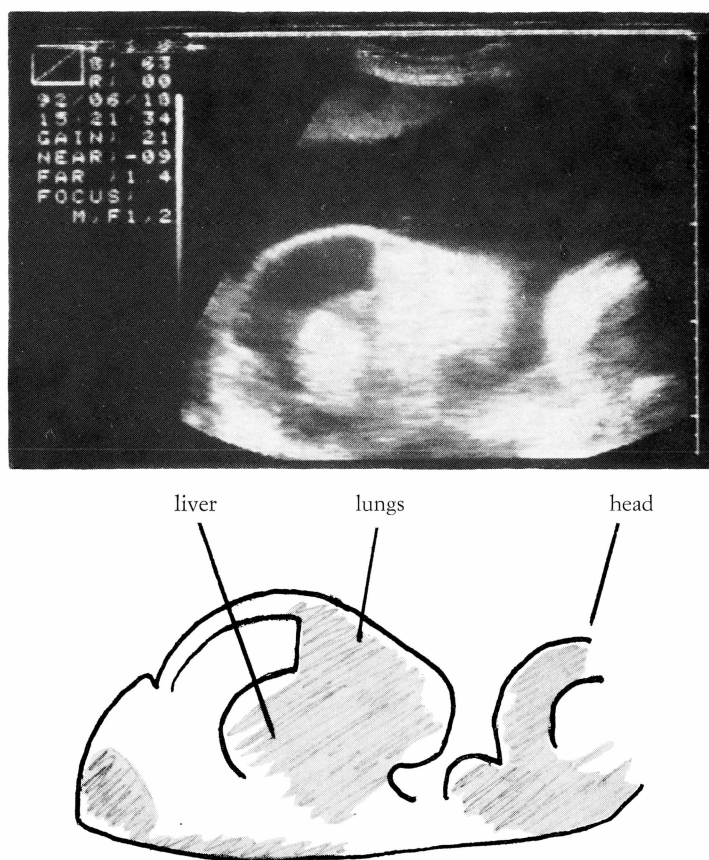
Case 1. Ultrasound showing hydramnios with fetus in longitudinal section.
